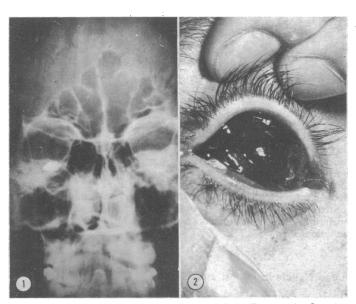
Case 96. X-ray appearances of intraocular pellet. FIG. 2—Case 96. Grossly disorganized eye after entry of pellet into globe.
